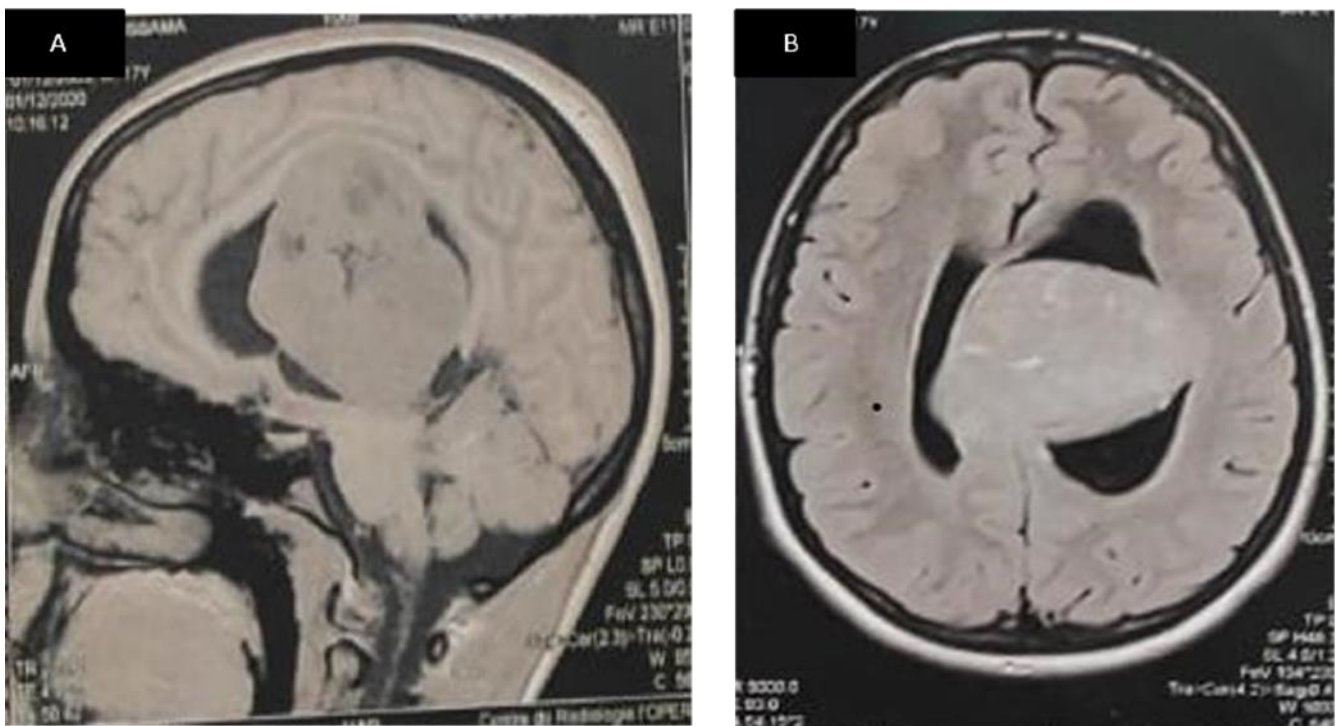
Magnetic resonance imaging (MRI) of the brain: Sagittal T1W (A), Axial T1W (B) revealed a large intraventricular lesion within the left lateral ventricle
